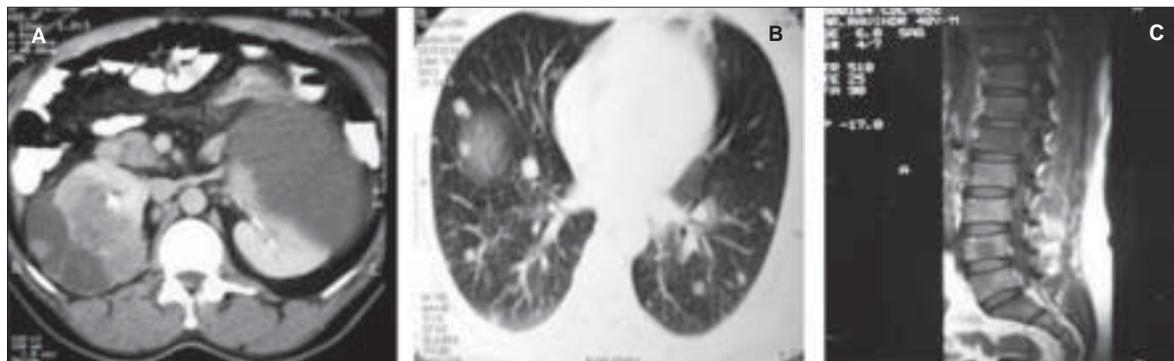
A. Computed tomography (CT) scan of abdomen showing bilateral renal masses B. CT scan of chest showing multiple pulmonary metastases C. Magnetic resonance imaging (MRI) scan showing metastasis to L4 vertebra
